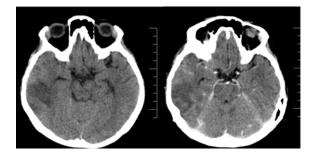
Another case of uncorrected diagnosed herpes simplex encephalitis; CT shows gyriform enhancing ill-defined hypodense area at the right temporal lobe, could be herpes simplex encephalitis. Final diagnosis was toxoplasma encephalitis by therapeutic treatment
